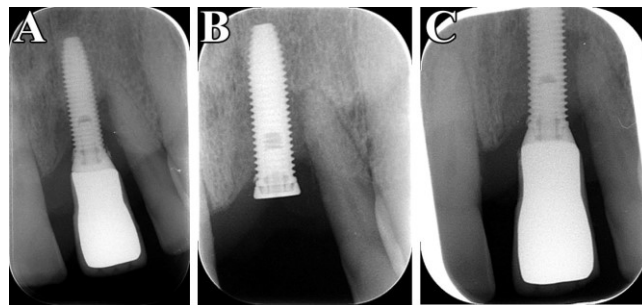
Example of x-ray image of an implant in three different moments: A) before the therapy, B) 1 month after the treatment and C) 8 months after the treatment
